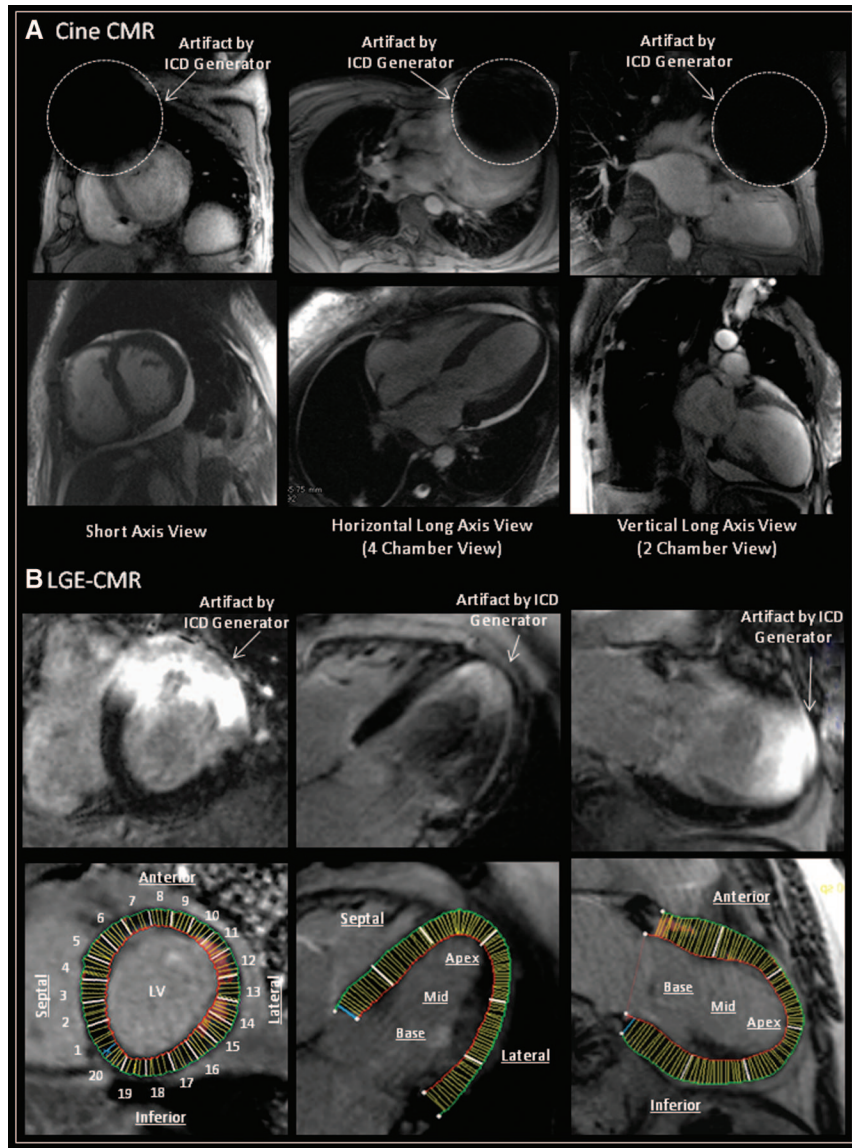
Methodology for measurement of artifacts on cine cardiac magnetic resonance imaging (CMR) and late gadolinium-enhanced CMR (LGE-CMR). Artifact size on steady-state free precession (SSFP) cine and LGE-CMR was measured in short-axis (SA), horizontal long-axis (HLA), and vertical long-axis (VLA) planes. A, The artifact size on cine CMR caused by the pacemaker and implantable cardioverter-defibrillator (PM/ICD) was measured. Percent sectors with any artifacts on cine CMR were also assessed in each plane. B, The regional artifact effects on LGE-CMR caused by the generator were quantitatively estimated in each plane (divided into 20 sectors in SA, 6 sectors in HLA, and 6 sectors in VLA planes, respectively).
